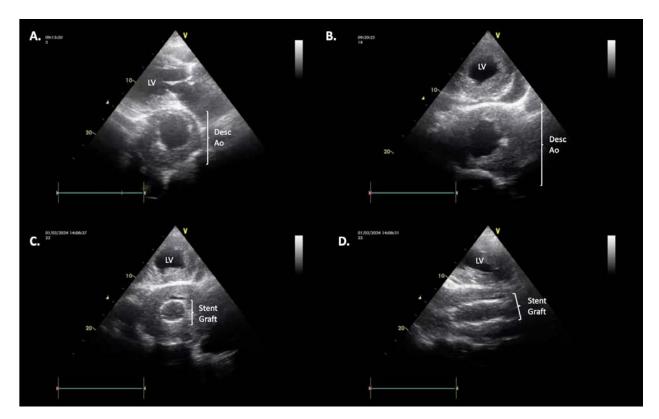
Echocardiography. Parasternal long (A) and short (B) axis view — prior to surgery. Short axis view — after surgery (C). Modified 2 chamber view — after surgery (D) Abbreviations: Desc Ao, descending aorta; LV, left ventricle
